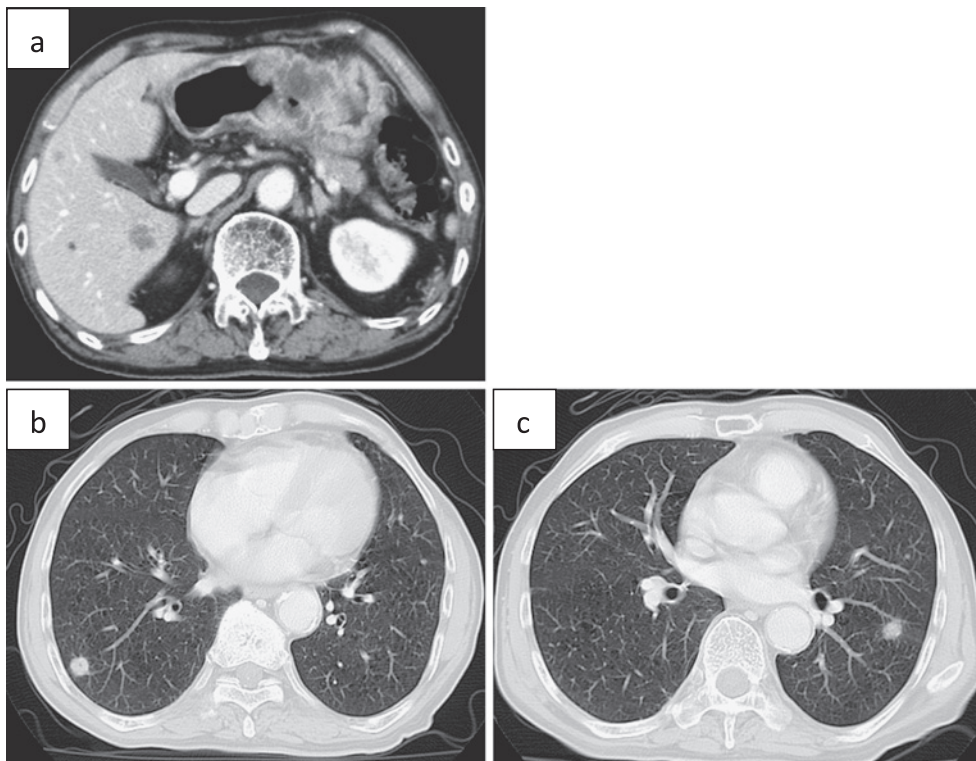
Abdominal computed tomography (CT) showing gastric wall thickness and nodules in the liver (a). Chest CT shows nodules in the lung (b) and (c).
